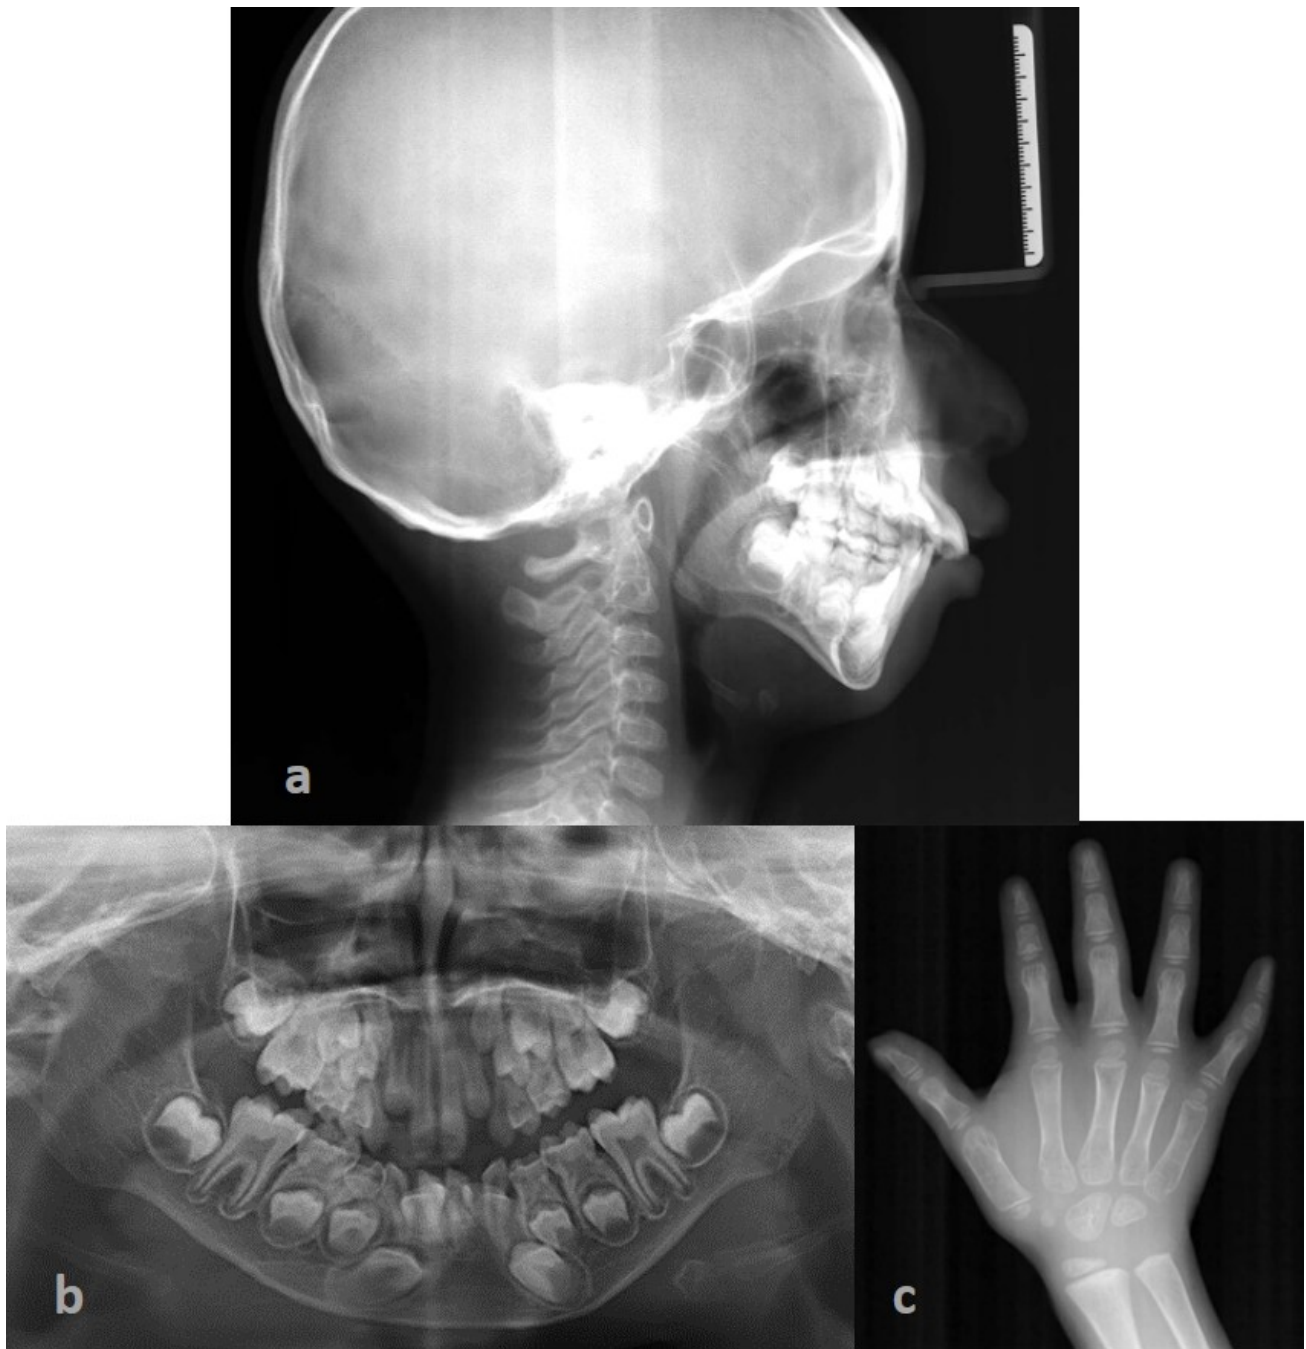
Radiographs. a. Lateral cephalometric radiograph, b. orthopantomograph, c. hand-wrist radiograph.
